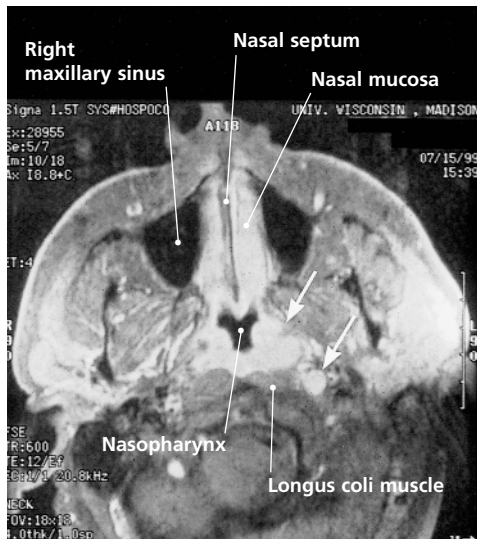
Sagittal magnetic resonance image in a patient with newly diagnosed squamous cell carcinoma of the nasopharynx. Arrows denote the primary tumor and a lateral retropharyngeal node metastasis. The patient was treated with high-dose radiation therapy and has been free of disease for two years.
